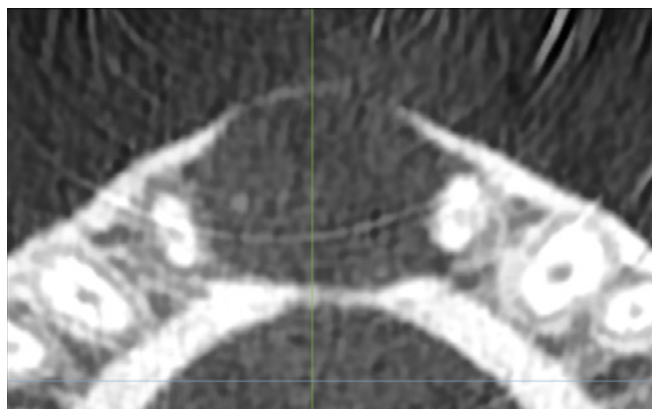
The CBCT scan reveals the extent of the lesion beneath four lower incisors, indicating that nearly all of the spongy bone has been lost.
